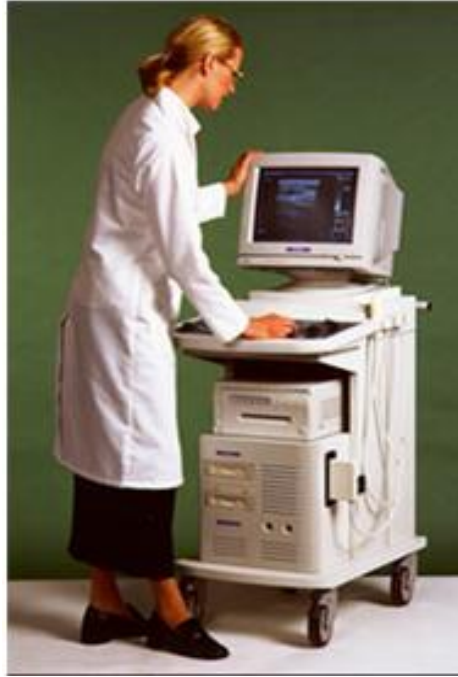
DIASUS ultrasound machine
